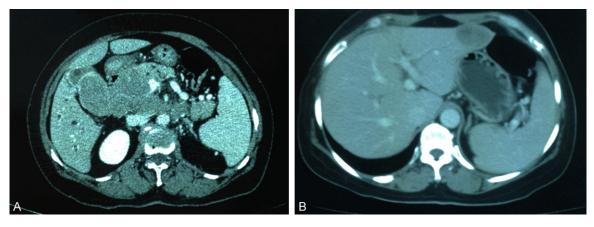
A: Enhanced CT scan showing malignant mass in the gallbladder, with portal and retroperitoneal lymph node metastases and main portal vein invasion. B: Liver metastasis was found at 6-month after radical resection for Patient 8, CT scan showing metastatic lesion at the left lateral lobe.
